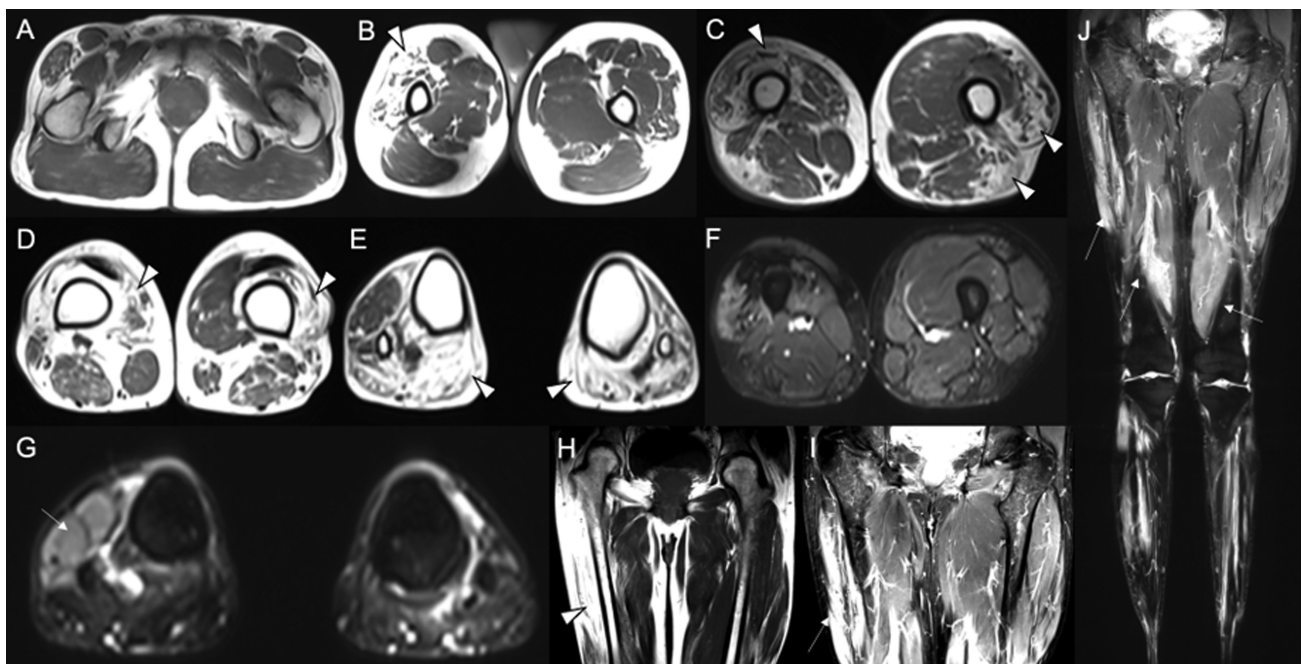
Muscle MRI studies. Axial (A-E) and coronal (H) T1-weighted MRI shows asymmetric amyotrophy and marked fatty replacement involving bilateral vastus lateralis, right vastus intermedius, left biceps femoris, right vastus medialis, left tibialis anterior, and bilateral heads of gastrocnemius. Axial (F,G) and coronal (I,J) STIR MRI shows hyperintensity involving right vastus lateralis and tibialis anterior.
